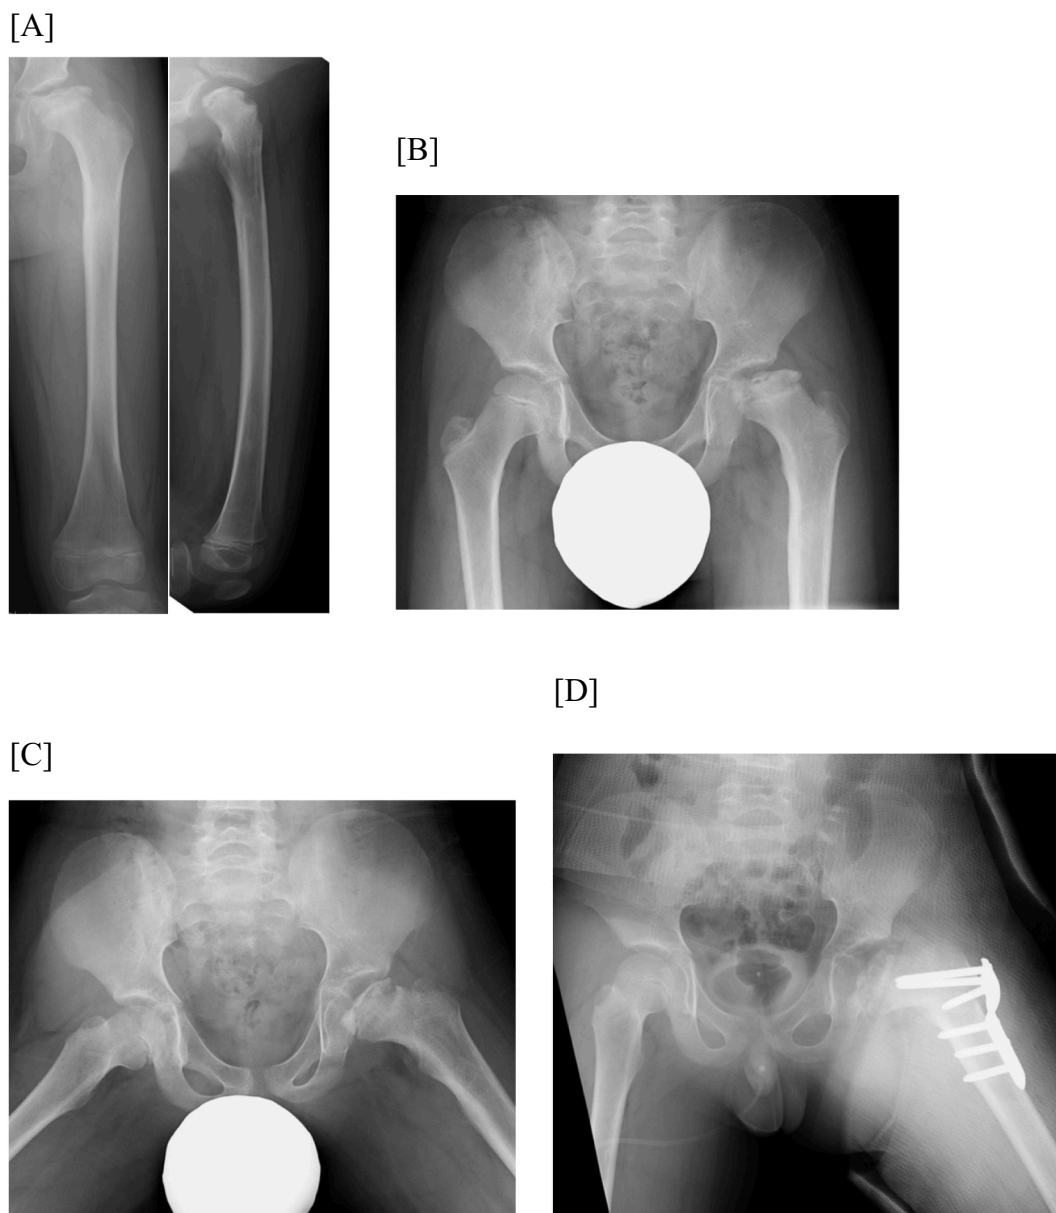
[A] Anteroposterior (AP) and lateral radiographs taken 18 months postoperatively. [B] AP radiograph of the pelvis showing the left-sided Herring grade C Legg-Calvé-Perthes disease. [C] AP radiograph of the pelvis showing the abduction of the bilateral hip joints. [D] AP radiograph of the pelvis with the hip spica cast after the left intertrochanteric varus osteotomy.
